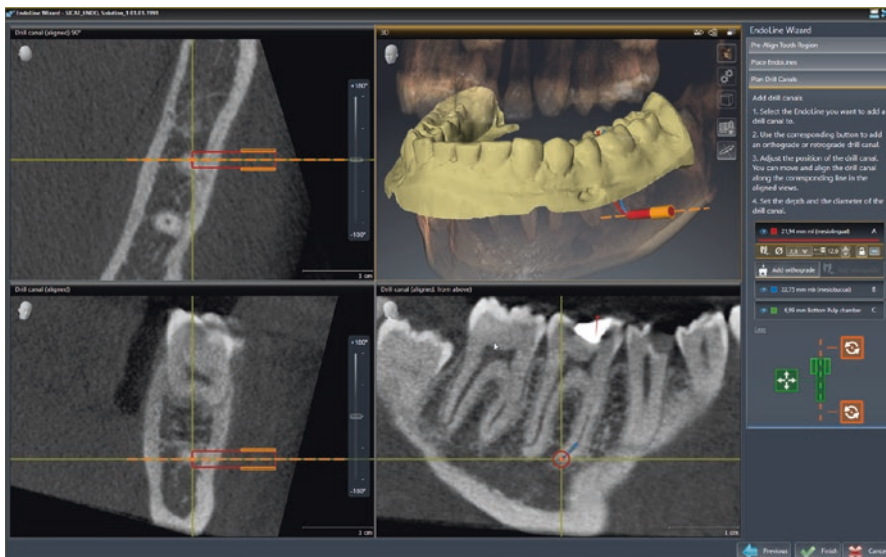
CBCT data and STL files are merged, and a virtual drill is placed to target the mesial root of tooth number 19. Thickness of the buccal plate, distance to the apex, and position of the different canals can be visualized to help decide whether the drill needs to be slightly tilted because of potential interference with the cheeks. Images from SICAT Endo® (SICAT, Bonn, Germany)
